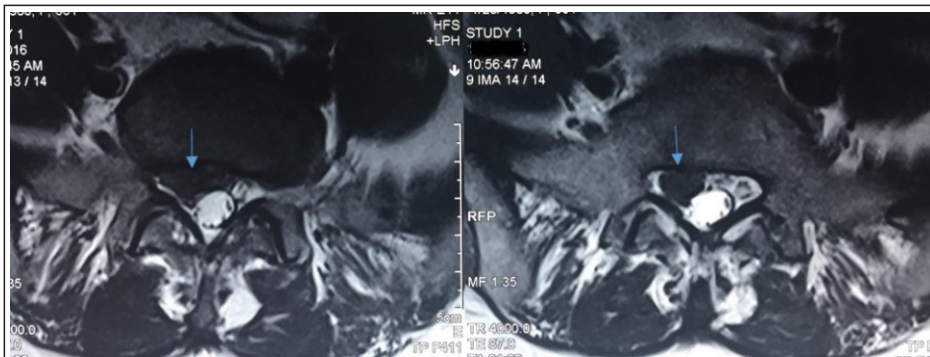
Axial T2-weighted MRI images of lumbar spine showing sequestered disk indenting the right (arrow) exiting root.
